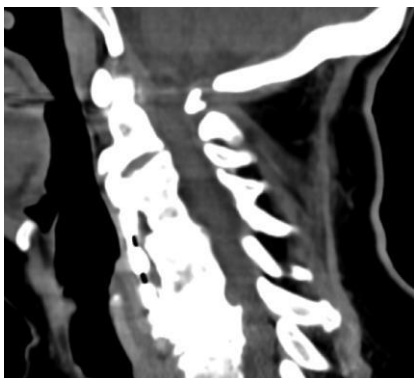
CT scan revealed kyphosis with severe spinal cord compression
